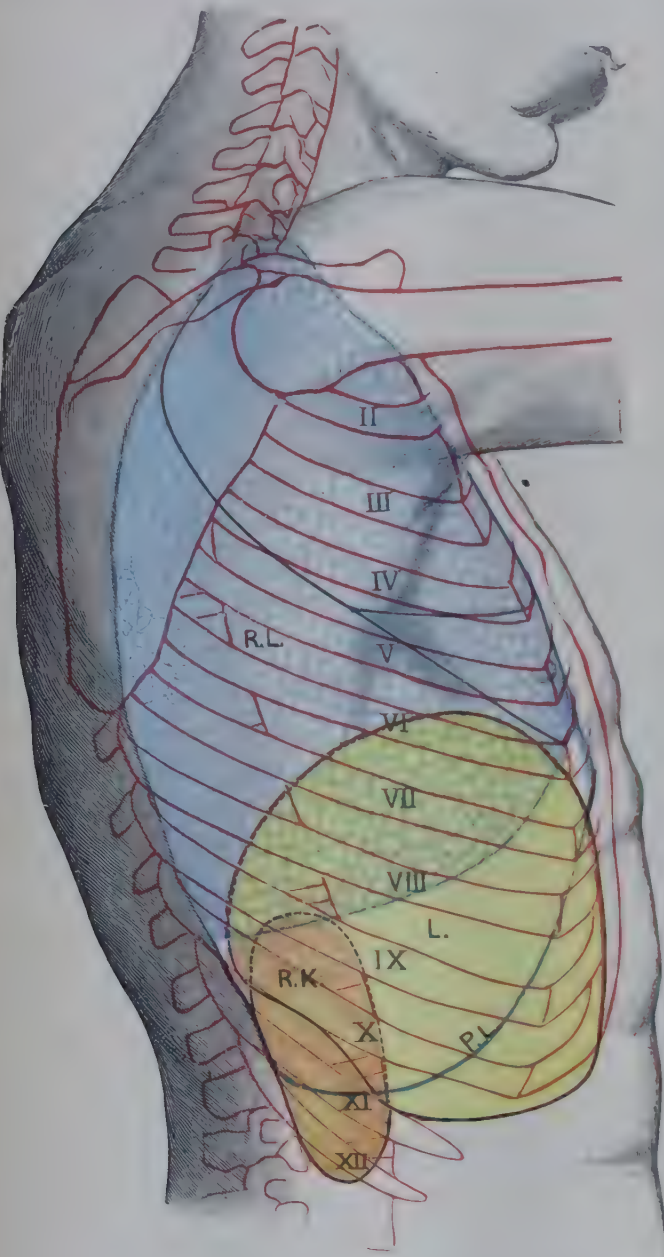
RIGHT LATERAL ASPECT OF TRUNK, SHOWING SURFACE TOPOGRAPHY OF VISCERA.
